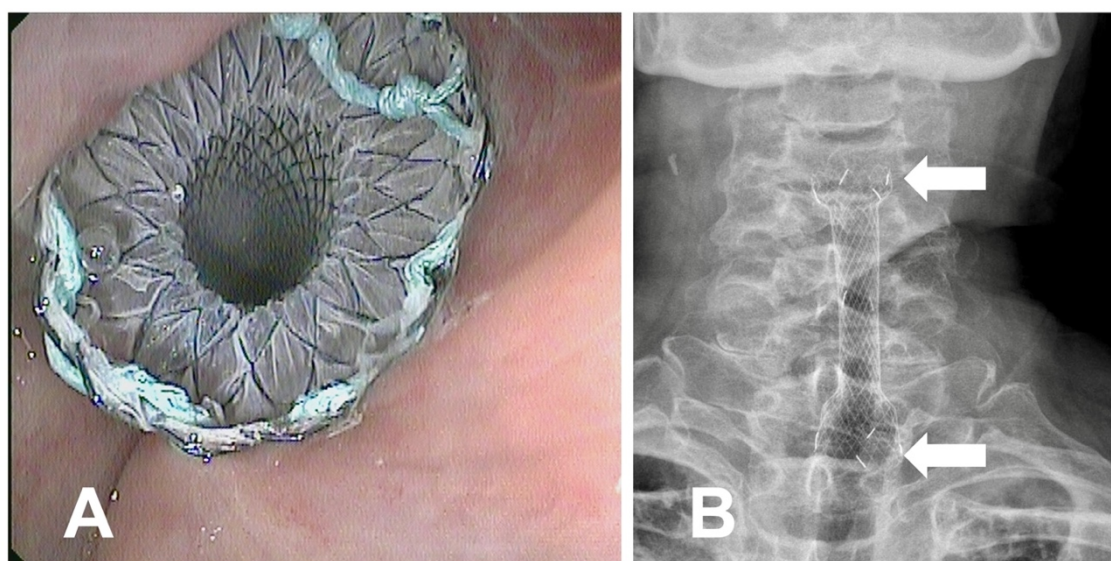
A) Insertion of a 16 mm wide, 6 cm long, fully covered, self-expanding metal stent (Niti-S cervical stent) into a malignant stricture in the cervical esophagus. B) X-ray of the cervical spine showing the stent after insertion
